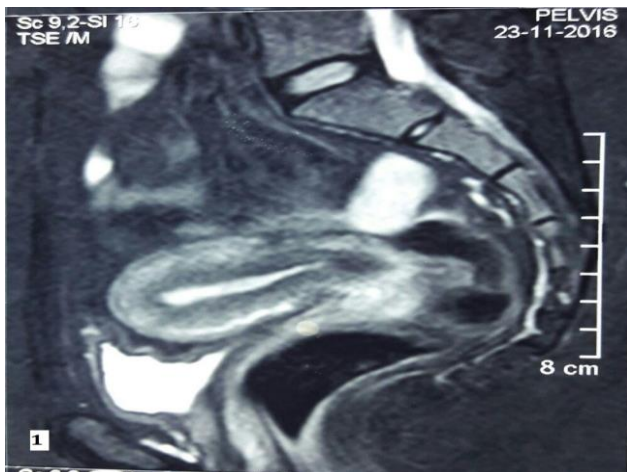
Preoperative MRI showing mild arcuate uterus with min fluid in vaginal cavity with vertical vaginal septum.
